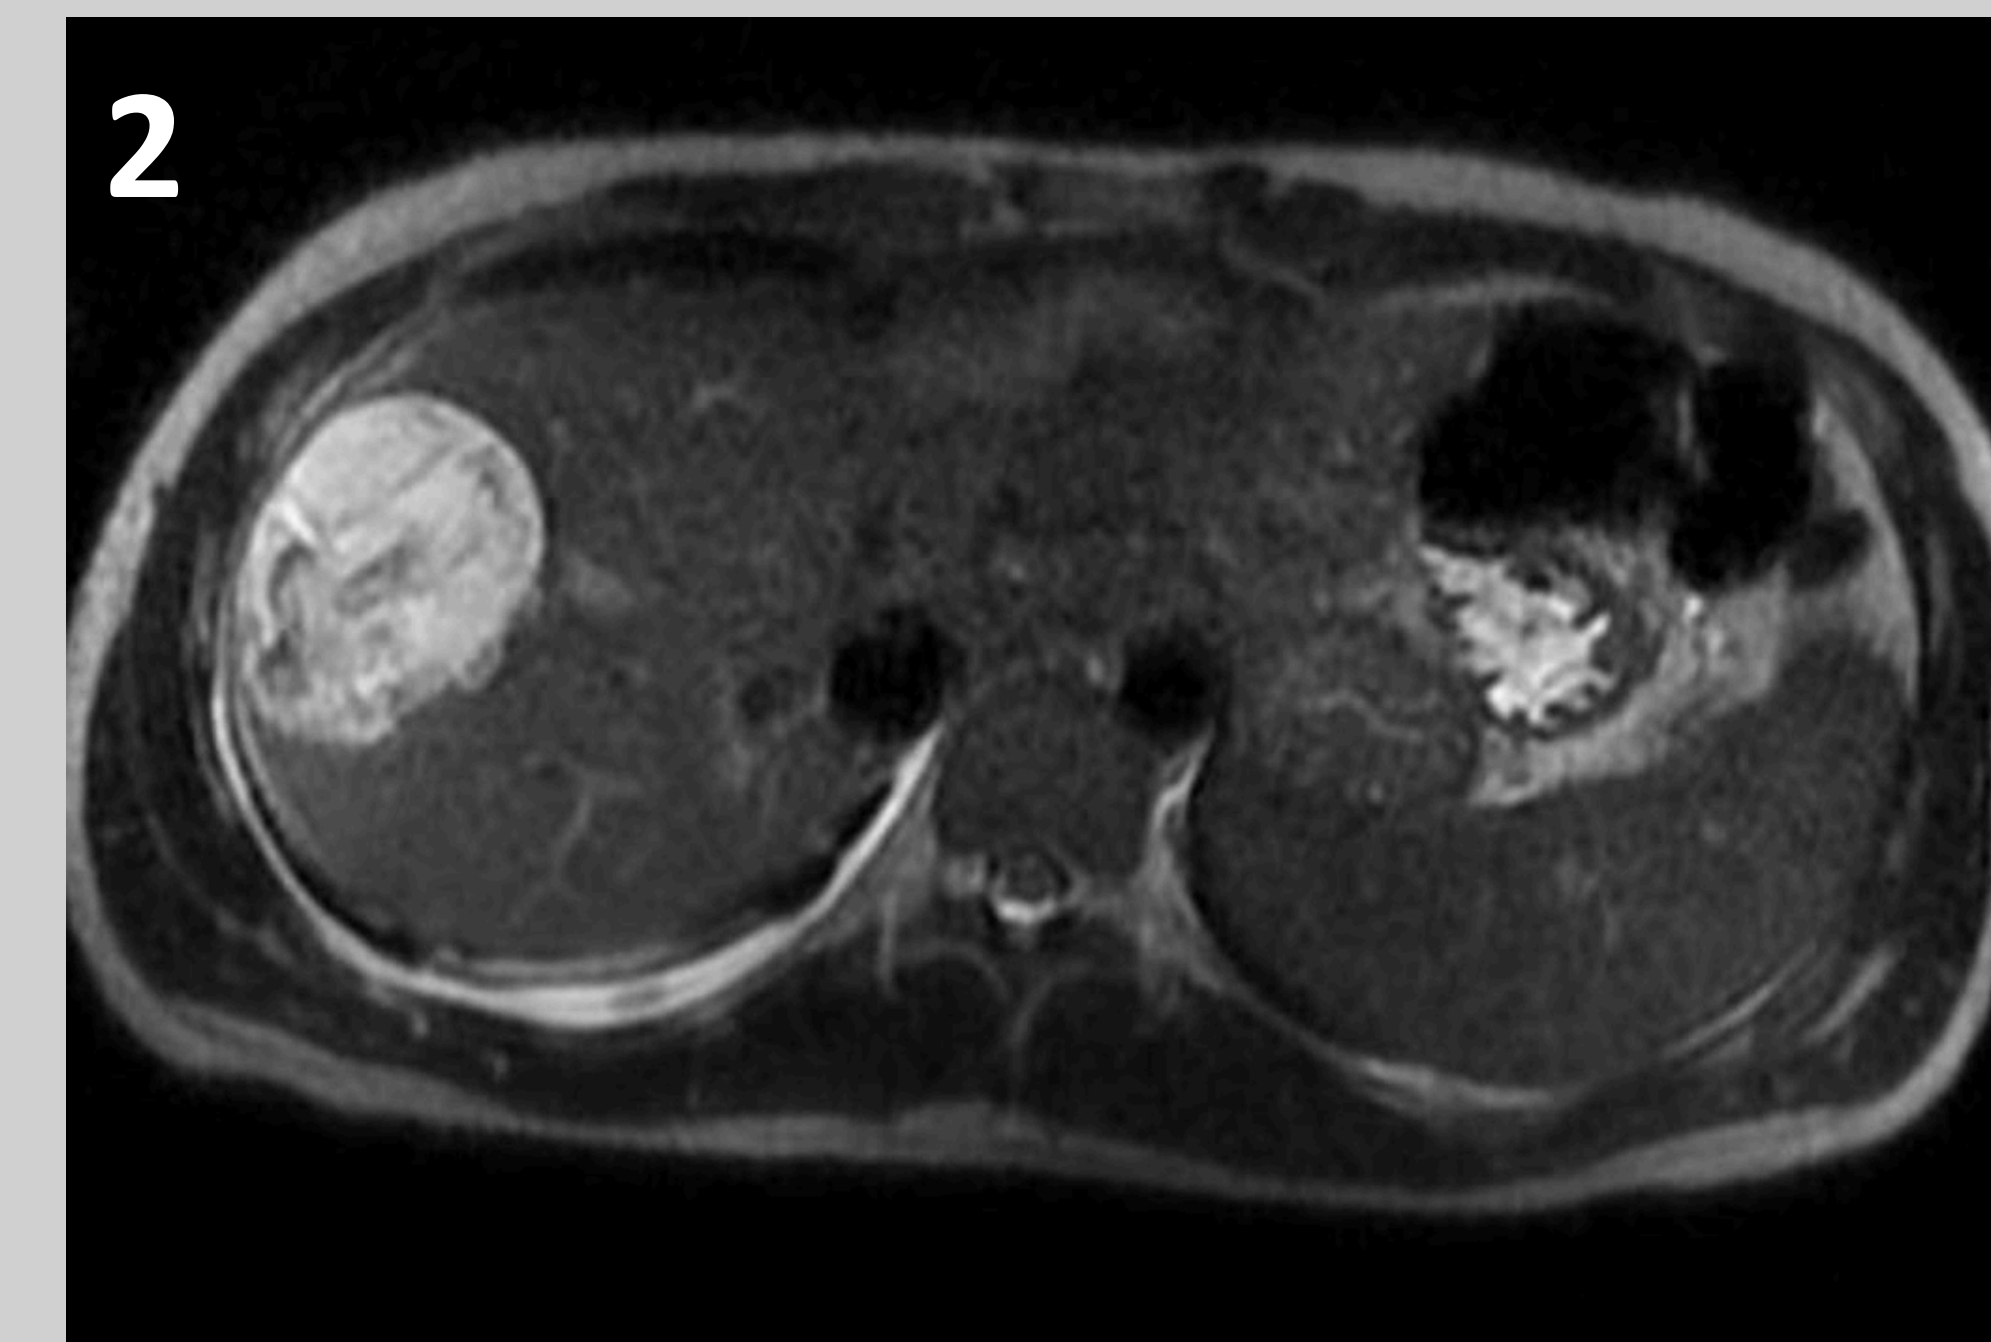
T2-weighted abdominal MRI demonstrating cystic features
